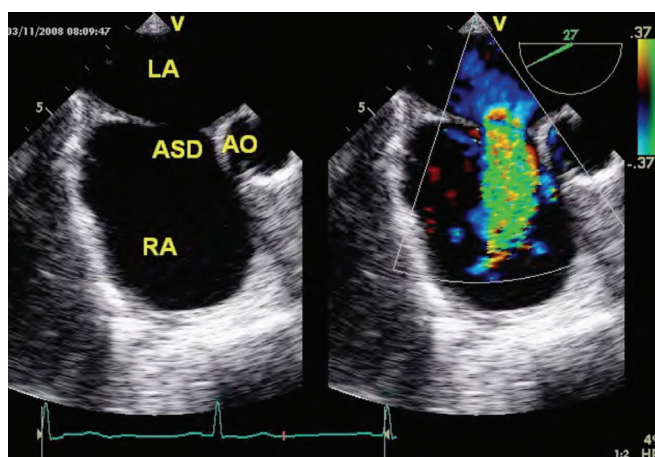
Transesophageal echocardiography (midesophageal view) showing the ascending aorta (AO), the left atrium (LA), the right atrium (RA), and the 13-mm ostium secundum defect (ASD), with the left-to-right atrial shunt seen in color Doppler.
